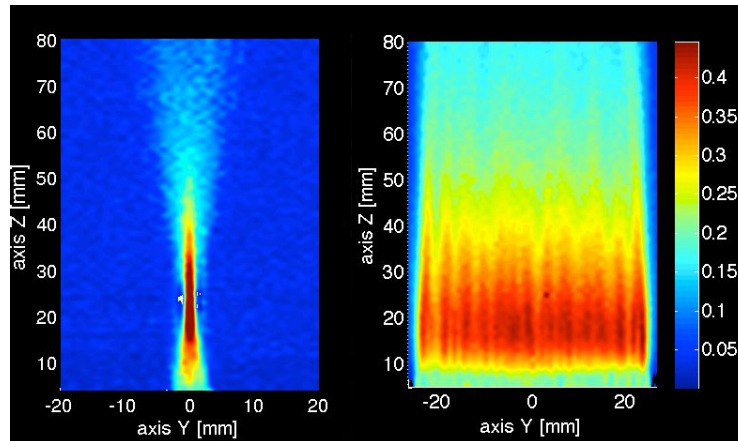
On the left is typical focused beam used in conventional ultrasound imaging. The right image shows a plane-wave beam pattern illuminating the entire extent of the array.
